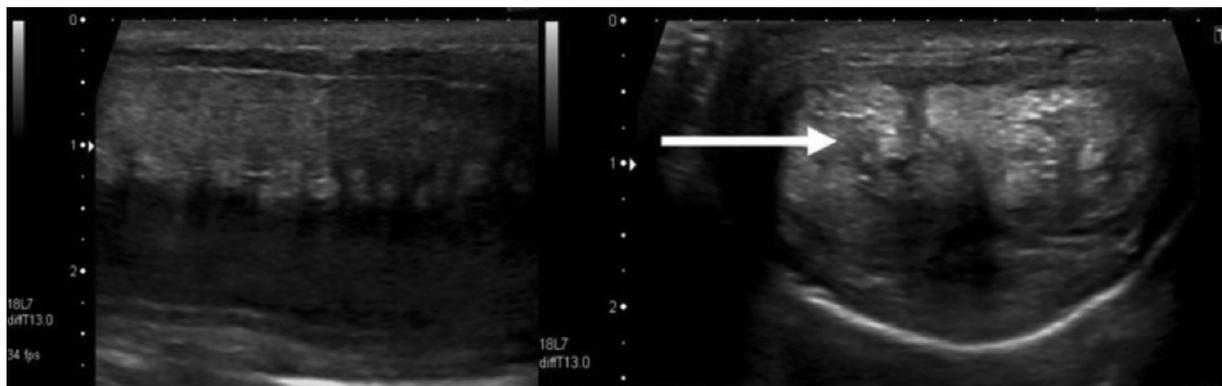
Long-standing ischemic priapism displayed by longitudinal ultrasonography (left) and transverse (right) images. The arrow identifies echogenic, distorted cavernosa reflecting significant corporal fibrosis. Image has been modified from the original source and used with permission: Halls JE, et al. *Br J Radiol.* 2012;85 Spec No 1(Spec Iss 1):S79-S85.
